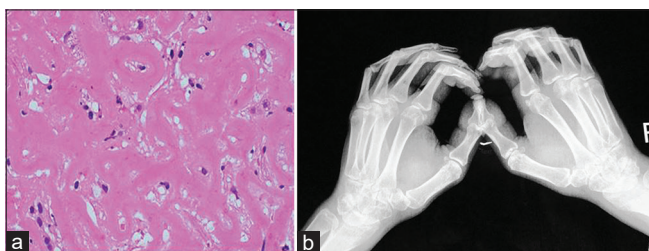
(a) Case 1 - Synovial biopsy section showing amorphous eosinophilic acellular material in the fibrocollagenous tissue along with mild mononuclear cell infiltrates and synoviocytes. (b) Case 2- X-ray of the hands showing joint deformities
